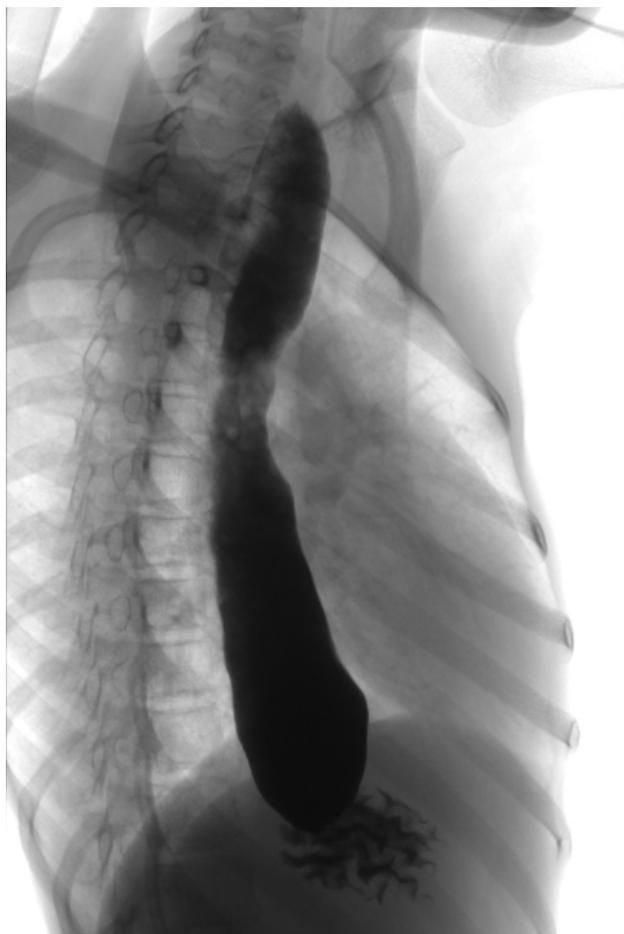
Upper gastrointestinal X-ray with contrast - normal anatomy of the digestive tract
